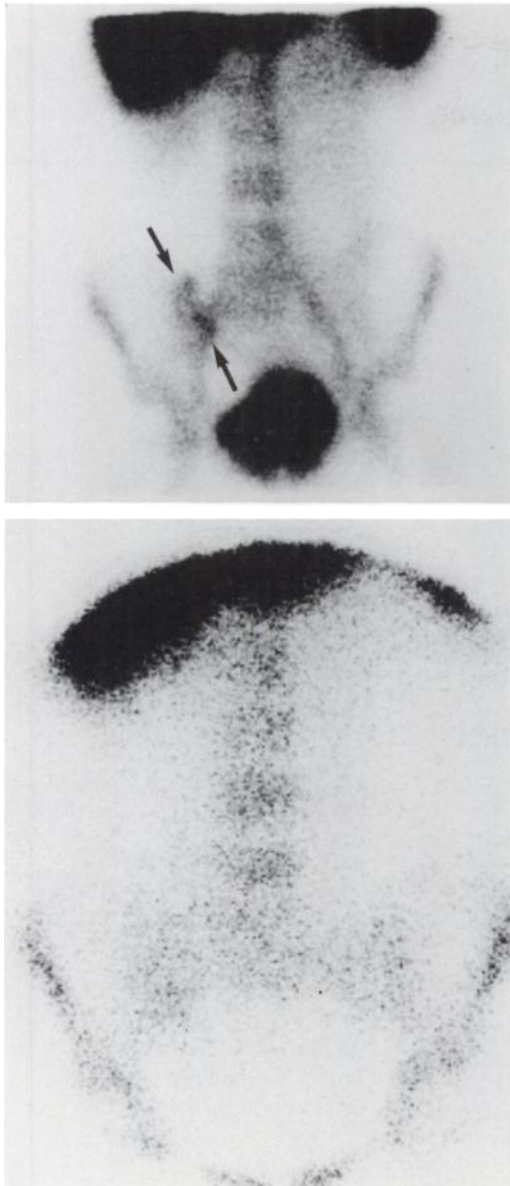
Patient 6. Crohn's disease of the small bowel. Discordant images. Clear pathologic activity in the terminal ileum (between the arrows) on the ^{99m}Tc -WBC image (top). Normal ^{111}In -granulocyte scintigram (bottom).
